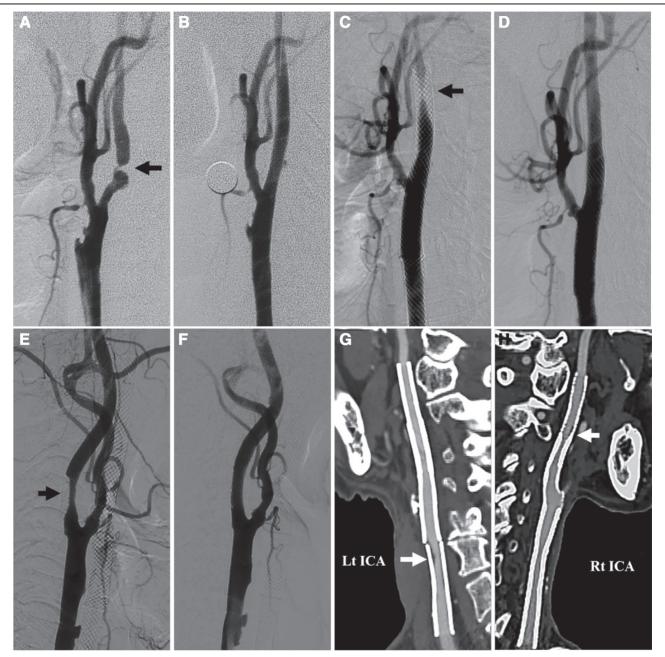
A 74-year-old male who had prior HNRT. He had carotid angioplasty and stenting (CAS) in 2008 for left internal carotid artery 98% stenosis and common carotid artery ulcerative plaque (A) without residual stenosis (B). Repeated stenting after 15 months for 95% restenosis (C) was performed with good results (D). He had CAS in 2014 for right internal carotid artery 70% stenosis (E) with postprocedural patency (F). Repeated right-sided stenting was performed in 2018 for another 80% stenotic lesion and 50% restenosis. Both sides revealed mild restenosis less than 50% in the last follow-up computed tomography angiography (CTA) in 2019 (4G–H).
